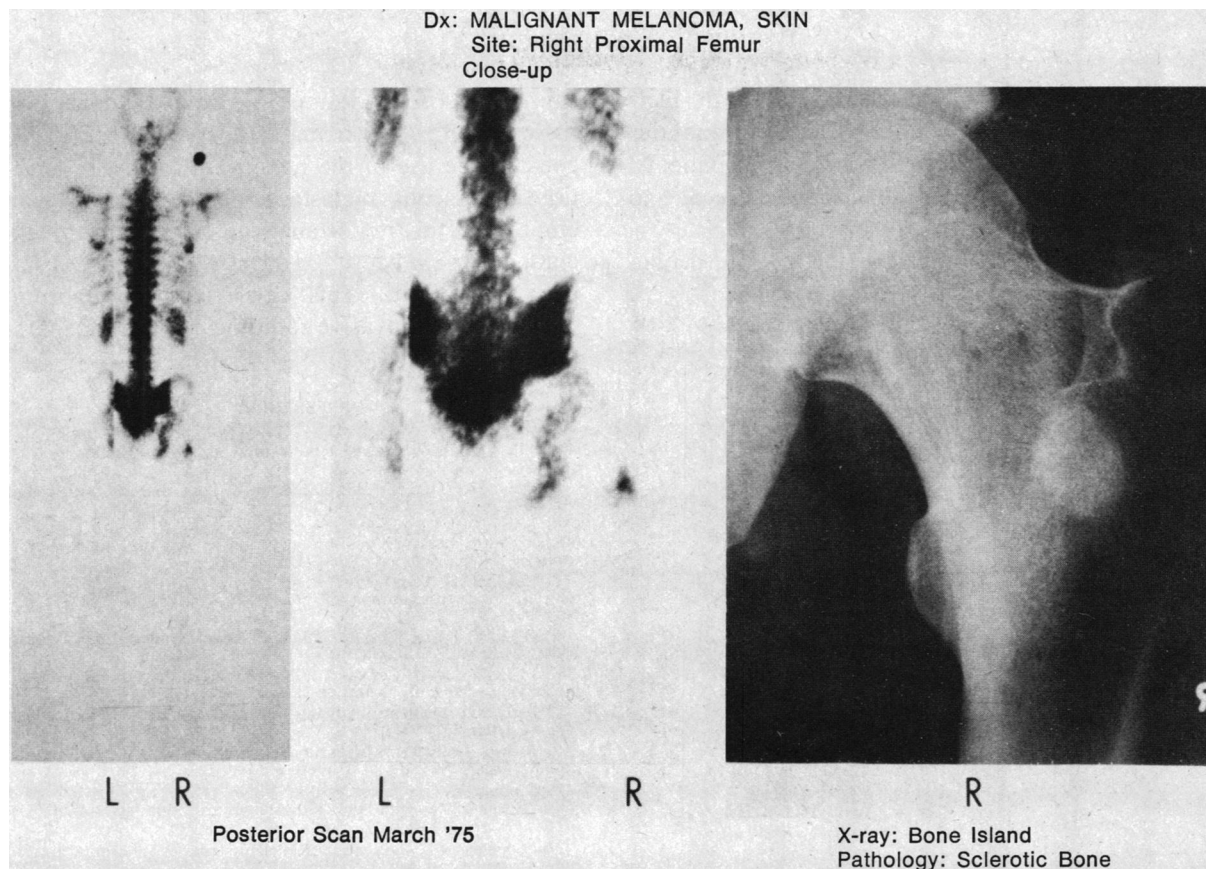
Bone scan of a 32-year-old man with malignant melanoma of the skin. A single focus of increased radioactivity is seen in the right proximal femur. The radiograph showed a lesion indicative of a bone island. Biopsy of the area showed sclerotic bone. Because bone islands are not thought to be positive on scan, this unusual case has been separately reported.¹⁴
